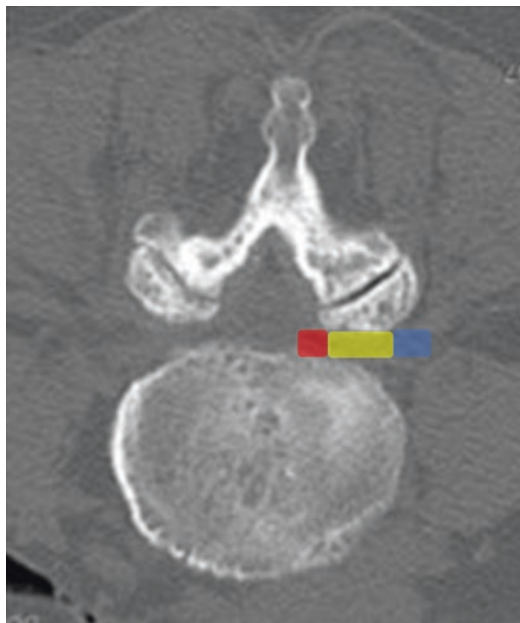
The lateral zone of the spinal canal on the axial CT image can be classified into three zones. From the medial to lateral are subarticular zone (red), foraminal zone (yellow), and extraforaminal zone (blue)
